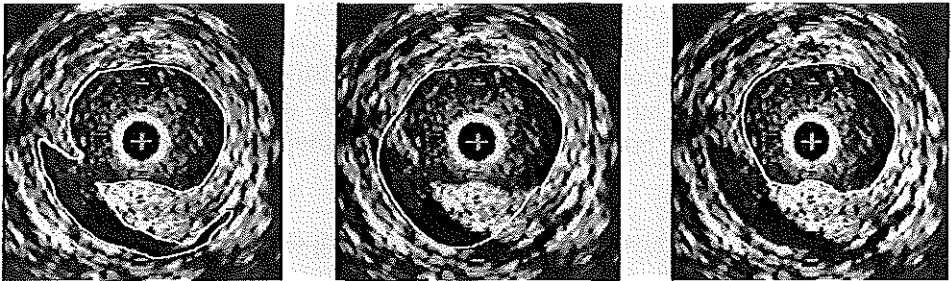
Identical intravascular ultrasound cross-sections showing a dissection with the results of manual and automated analysis. Left panel shows the manually assessed contour of lumen area. Middle and right panel show 2 incorrect analyses of lumen area derived with the automated system.
